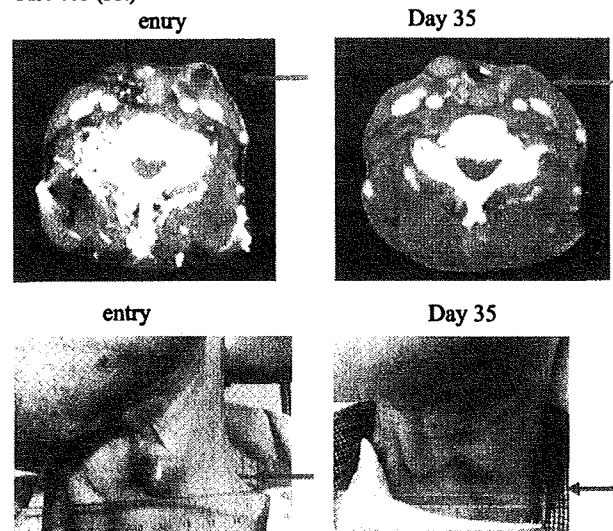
Computed tomography findings and photographs of case 003 before and after treatment. The arrows indicate the tumor lesion
